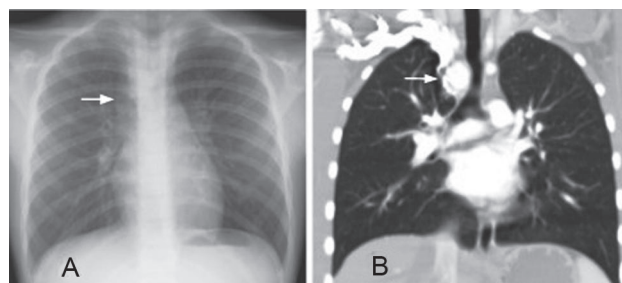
Imaging studies from case 3. A: Chest radiograph, showing right aortic arch (arrow). B: Computed tomography angiogram, showing the location of the vascular ring, with dominant right arch (arrow). The trachea is narrowed at the level of the ring.
